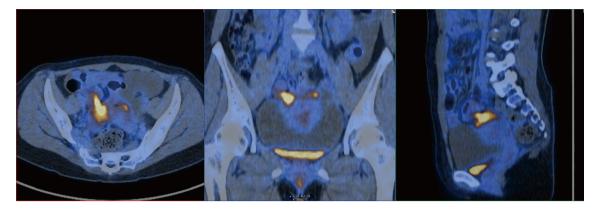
PET-CT revealed a right pelvic mass with an increased uptake of FDG. FDG, ¹⁸F-Fluorodeoxyglucose; PET-CT, positron emission tomography-computed tomography.
